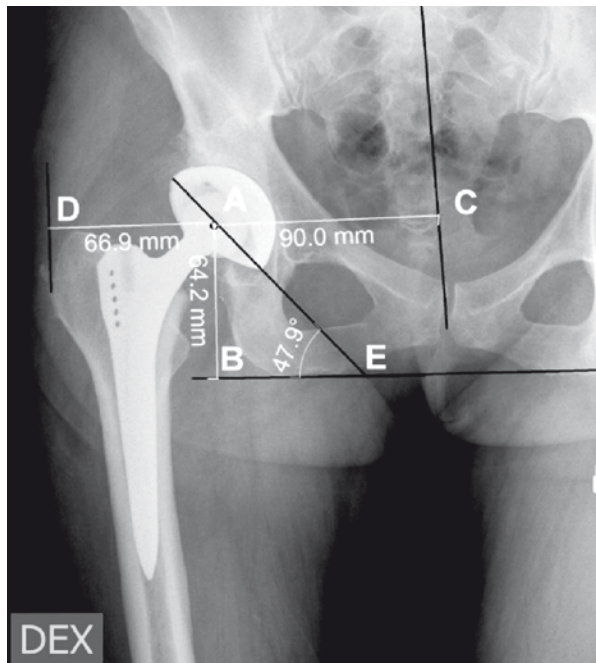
Postoperative measurements in A-P radiograph– THR of the right hip joint with uncemented EP(W.Link T.O.P. acetabular component of endoprosthesis located into the primary socket,SLPluss stem and ceramic ball head used; AB–the vertical location of the rotation center of the hip joint, AC– the horizontal location of the rotation center of the hip joint; AD– the offset; angle AEB– the inclination angle of the acetabular component of endoprosthesis into the pelvis)
